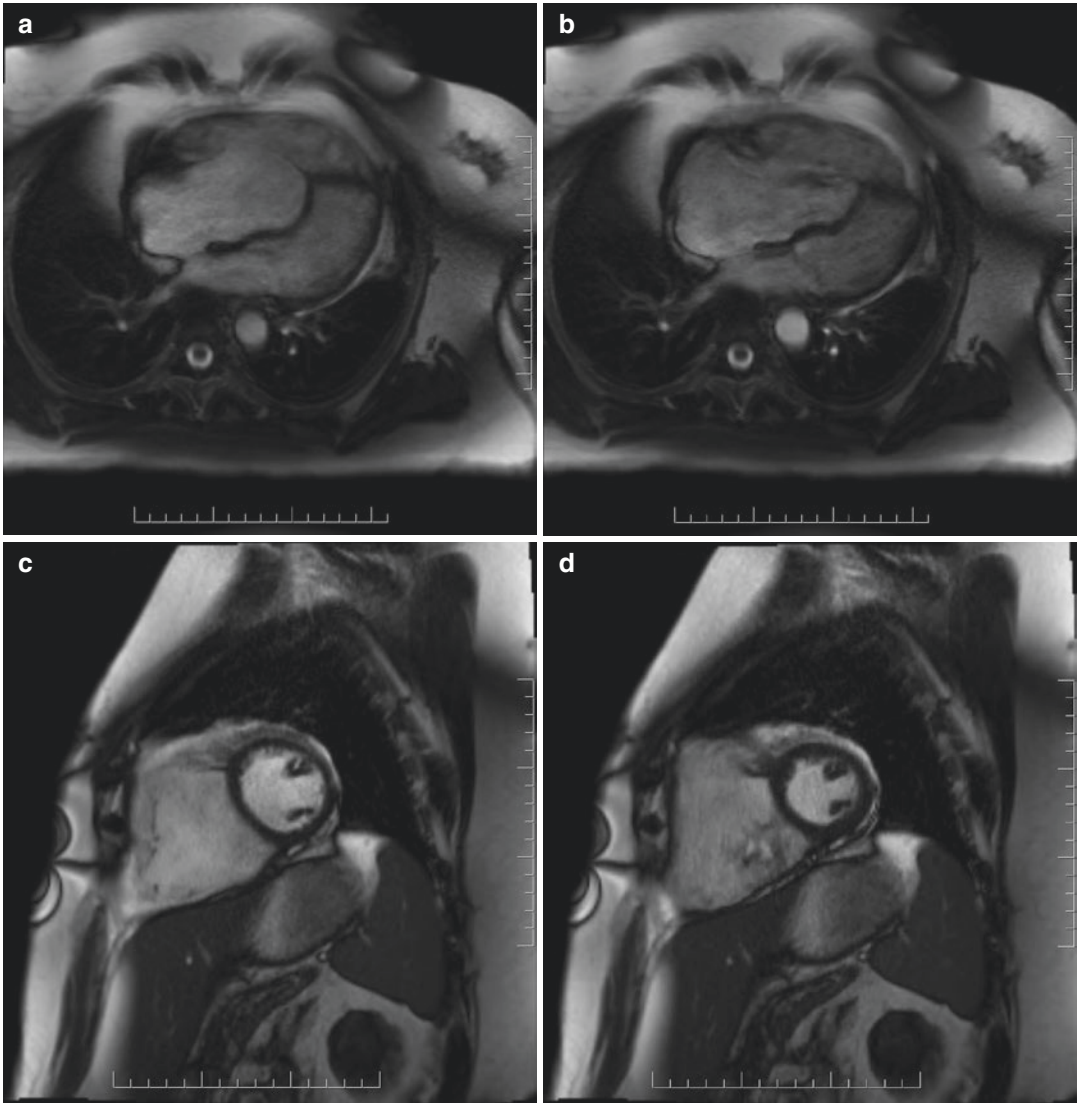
Cardiac magnetic resonance imaging of severe tricuspid regurgitation in Ebstein anomaly; (a) four chamber view in diastole, (b) four chamber view in systole, (c) short axis view in diastole, (d) short axis view in systole
